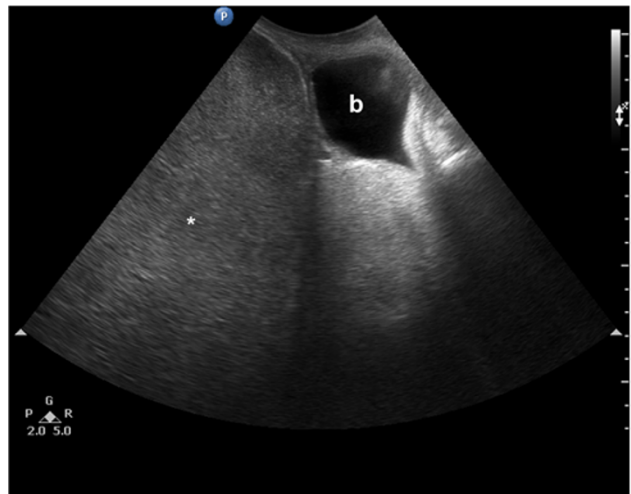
Sagittal ultrasound of bladder (*b*) and the discrete echogenic mass (*asterisk*) superior to it
